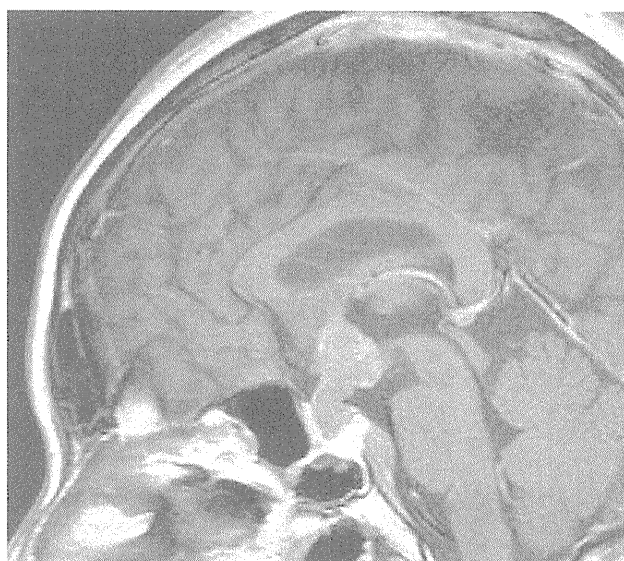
Sagittal magnetic resonance imaging view with gadolinium diethylenetriamine pentaacetic acid (Gd-DTPA) after the corticosteroid therapy reveal marked enlargement of the mass
